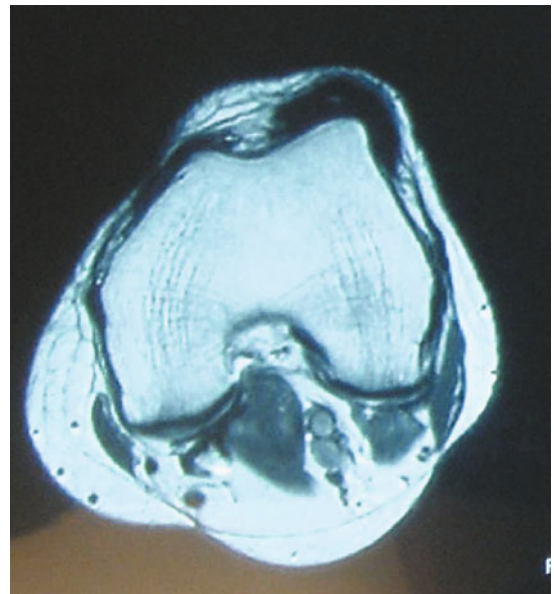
Magnetic resonance imaging shows persistent subluxation of the patellar tendon following patellectomy. The tendon snapped painfully across the lateral femoral condyle with flexion and extension of the knee. The insertion of a trochlear component provided a groove and solved the problem
